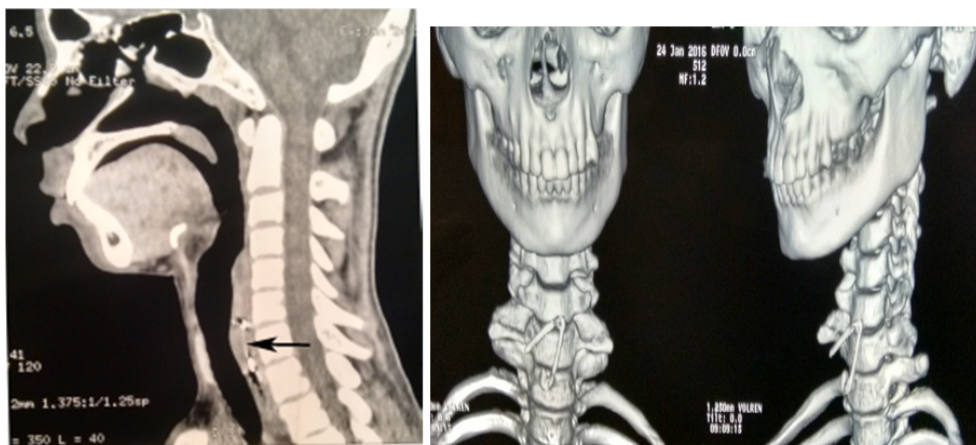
(A) CT scan on sagittal plane showing the safety pin (black arrow) on left hand side. (B) Reconstructed 3D images from CT scans on right hand side showing exact position and orientation of the safety pin.
